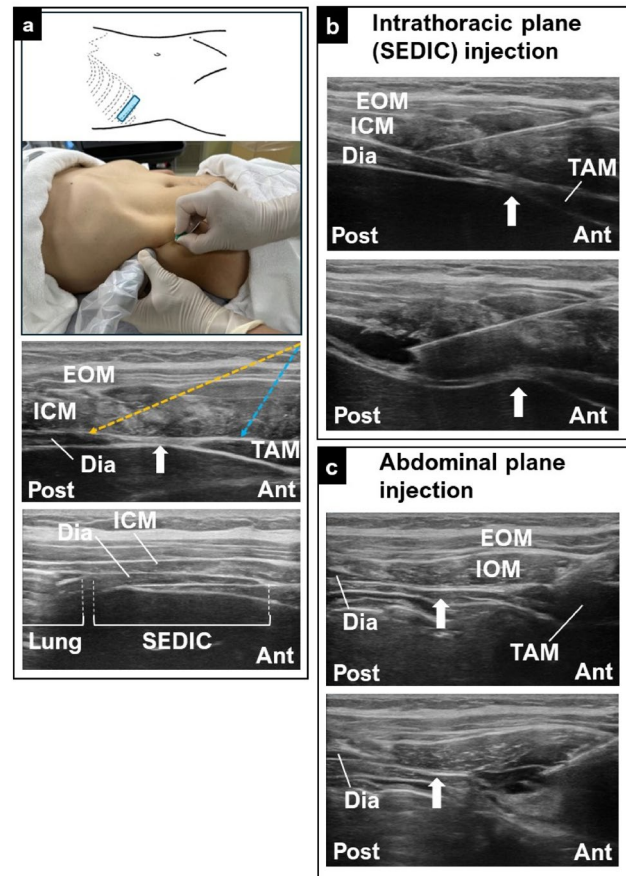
Transducer orientation and ultrasonographic image of thoracic plane (SEDIC) and abdominal plane injections. a Transducer orientation placed on the 10th intercostal space (upper panel) and the corresponding ultrasonographic image (middle panel). The orange and blue dotted arrows indicate the needle positions for the intrathoracic plane (SEDIC) and abdominal plane injections, respectively. The white arrow indicates the border between the diaphragm and transversus abdominis muscle. The lower panel displays the ultrasonographic image during maximum inspiration, showing the expansion of the lungs and anticipated spread of the SEDIC. b The ultrasonographic photographs showing the needle position of the intrathoracic plane (SEDIC) injection (upper panel) and image after local anesthetic administration (lower panel). The white arrow indicates the border between the diaphragm and transversus abdominis muscle. Local anesthetic spread into the abdominal plane was not observed. c The ultrasonographic photographs showing the needle position of the abdominal plane injection (upper panel) and image after local anesthetic administration (lower panel). The white arrow indicates the border between the diaphragm and transversus abdominis muscle. Local anesthetic spread into the intrathoracic plane (SEDIC) was not observed. *Ant* anterior, *Dia* diaphragm, *EOM* external oblique muscle, *ICM* intercostal muscle, *Post* posterior, *SEDIC* the space between the endothoracic fascia, diaphragm, and parietal pleura, *TAM* transverse abdominis muscle
